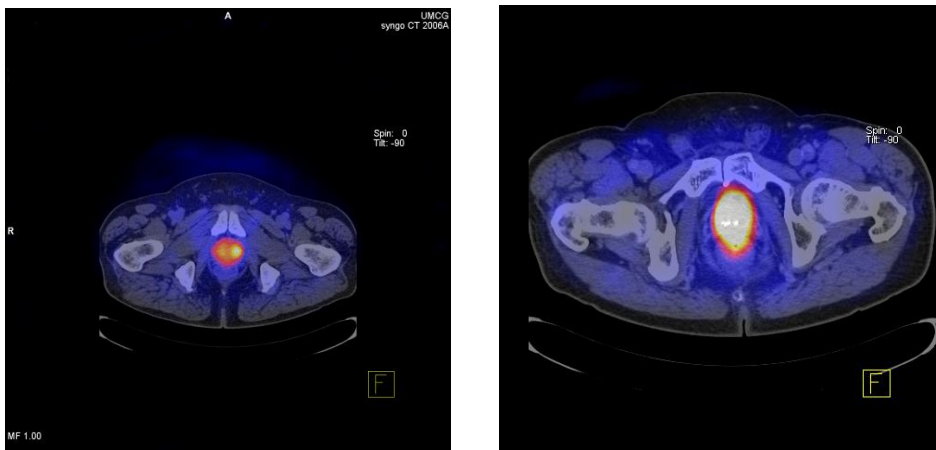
Two typical cases of focal(left) and diffuse (right) Chol-PET/CT.
